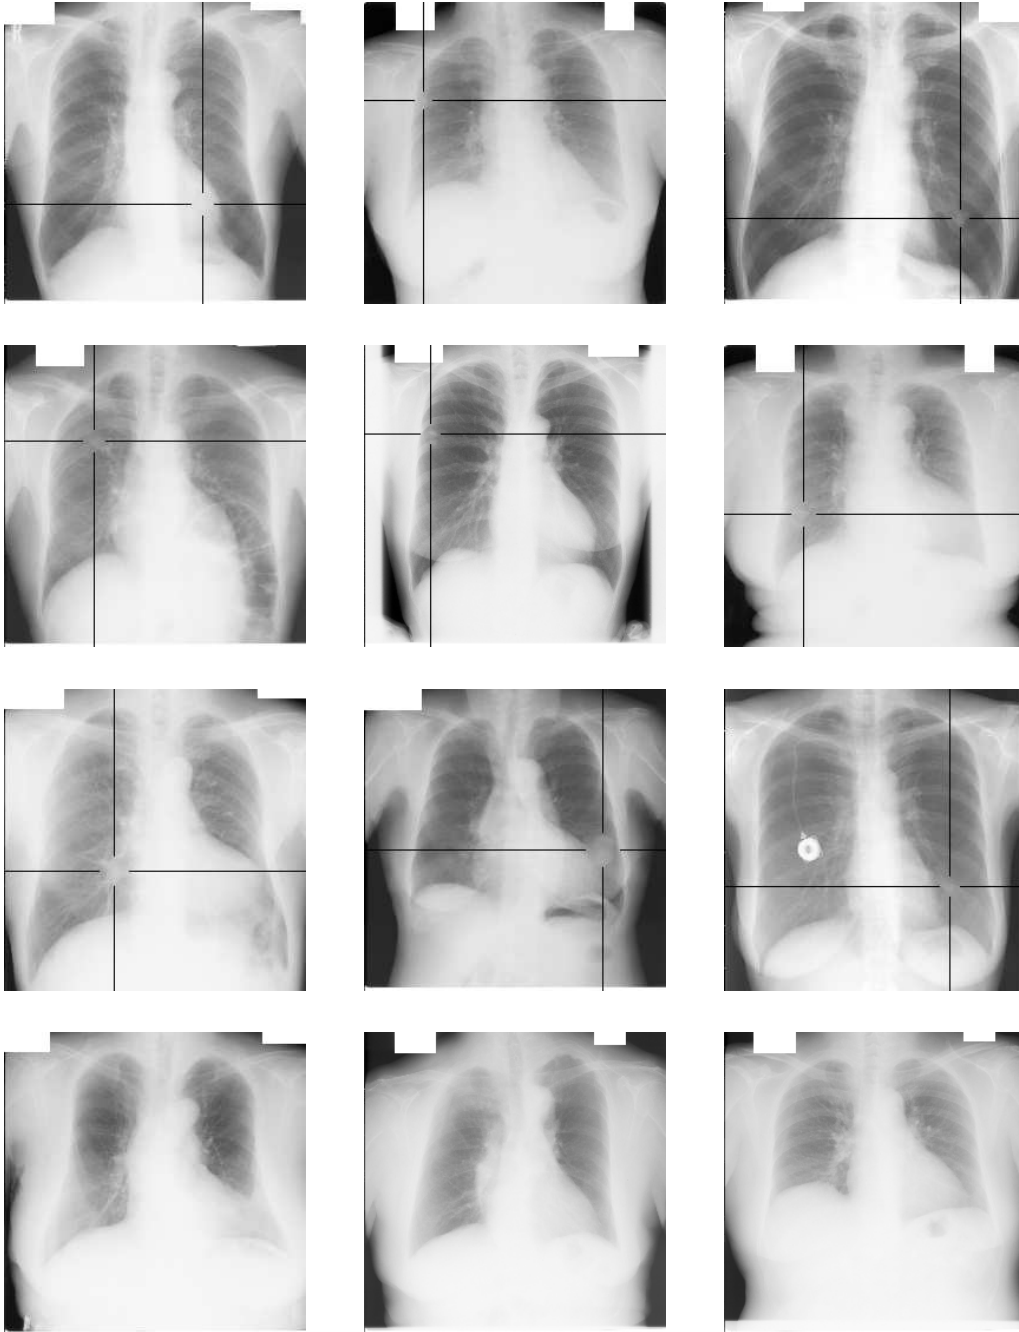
examples of chest radiographs in the JSRT Database*
